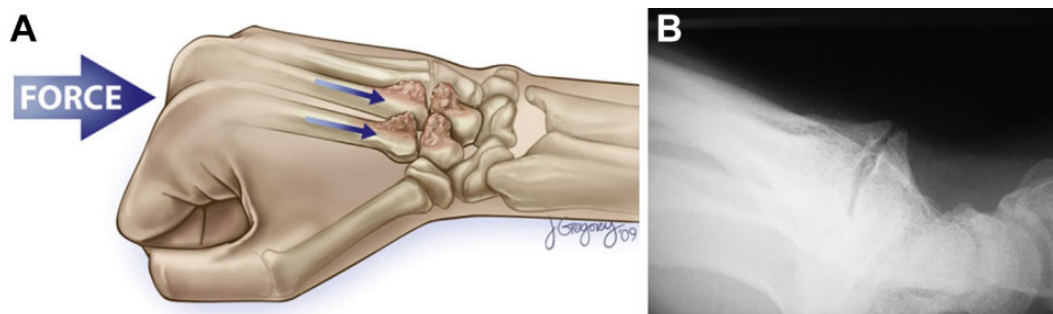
(A) Repetitive, traumatic axial loads from the metacarpophalangeal joints across the carpometacarpal joints are thought to be a cause of traumatic carpal boss formation. (B) Radiograph demonstrating traumatic carpal boss formation characterized by hypertrophic spur formation dorsally and articular degenerative changes. (Reproduced with permission from Melone CP Jr, Polatsch DB, Beldner S. Disabling hand injuries in boxing: boxer’s knuckle and traumatic carpal boss. *Clin Sports Med.* 2009;28[4]:609-621.)
